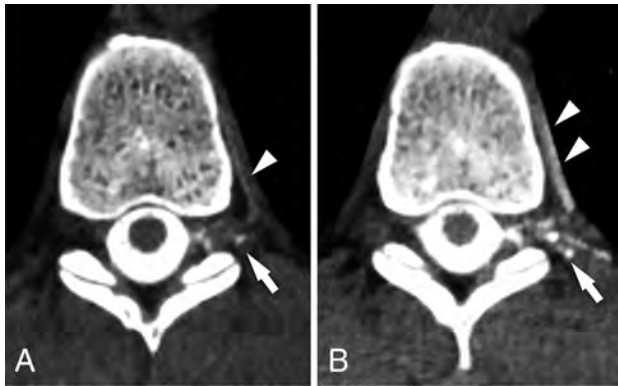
CSF venous fistula visualized best on decubitus CTM. Axial prone CT myelogram (A) shows subtle filling of a network of paraspinous veins (arrowhead) lateral to the nerve root and in the adjacent spinal segmental vein (arrowhead). Axial image (B) from a decubitus CTM performed after dynamic myelography on a subsequent day shows increased filling of the lateral veins (arrow) and segmental vein (arrowheads), making the CVF much more conspicuous.
